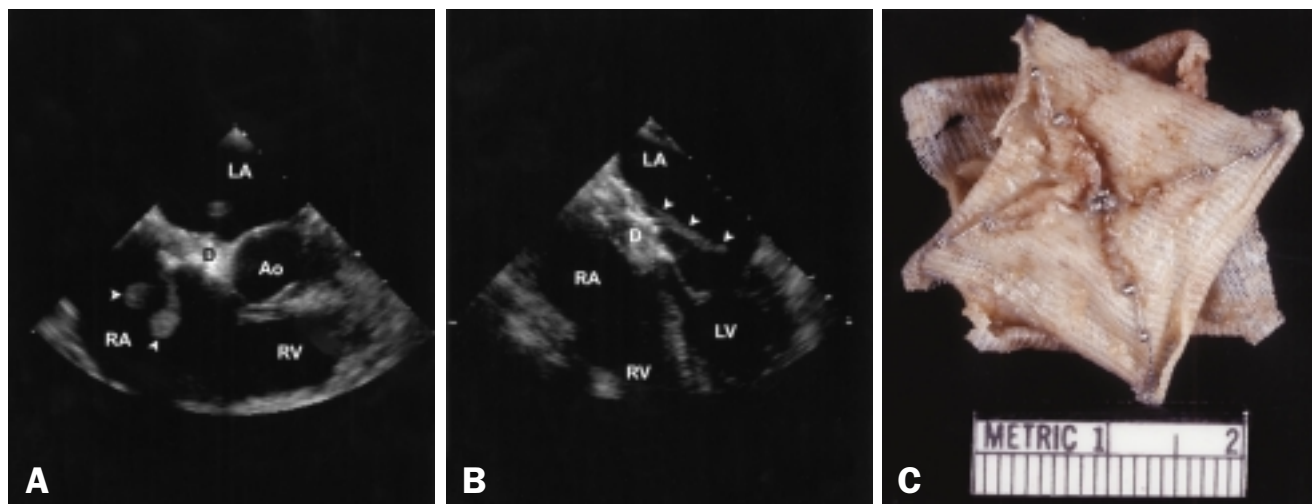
A and B, Transesophageal echocardiographic images showing thrombus (arrowheads) on both sides of the patent foramen ovale closure device. C, Surgically removed CardioSEAL device showing residual thrombus. Ao = aortic valve; D = closure device; LA = left atrium; LV = left ventricle; RA = right atrium; RV = right ventricle.
